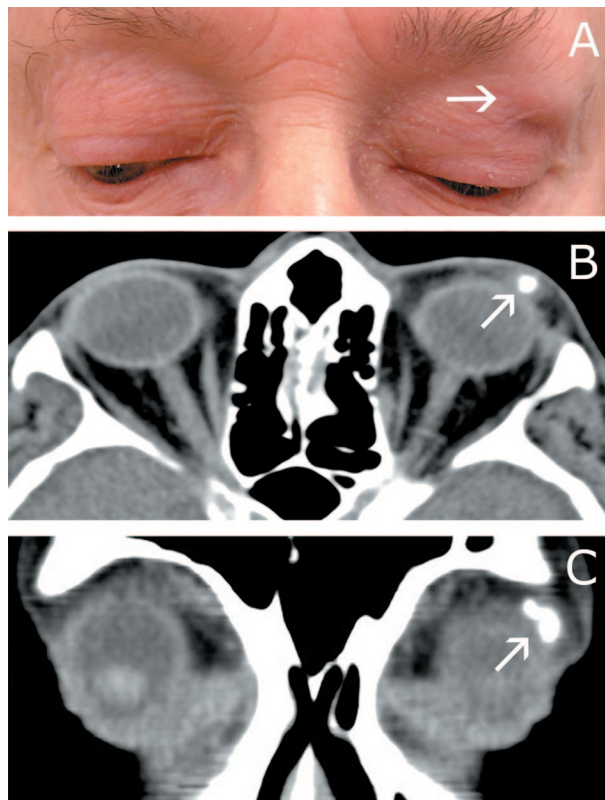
A, Clinical appearance of tumor protruding through left upper eyelid (arrow). B, Axial CT shows a calcified mass (arrow) at the lateral edge of left eye without signs of bone or skin infiltration. C, Coronal view shows tumor (arrow).
